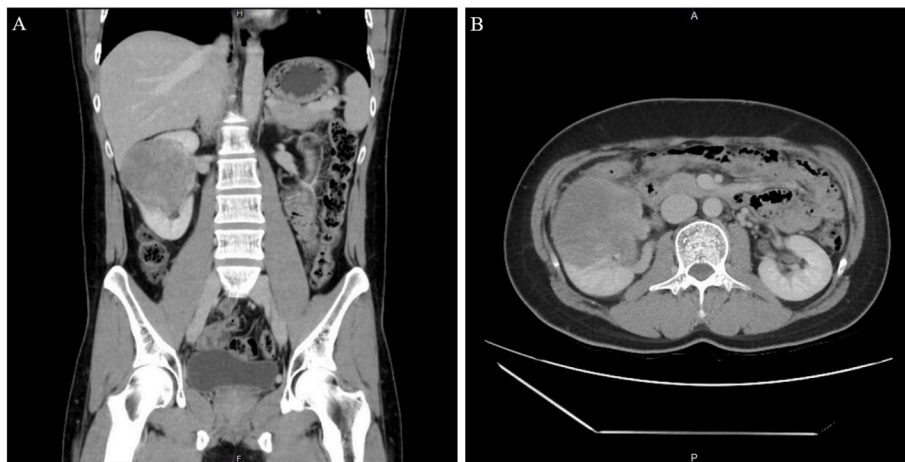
Abdominal CT (A, coronal view; B, axial view) depicting a well-circumscribed heterogeneous enhanced mass at the right kidney with perirenal fat invasion.
